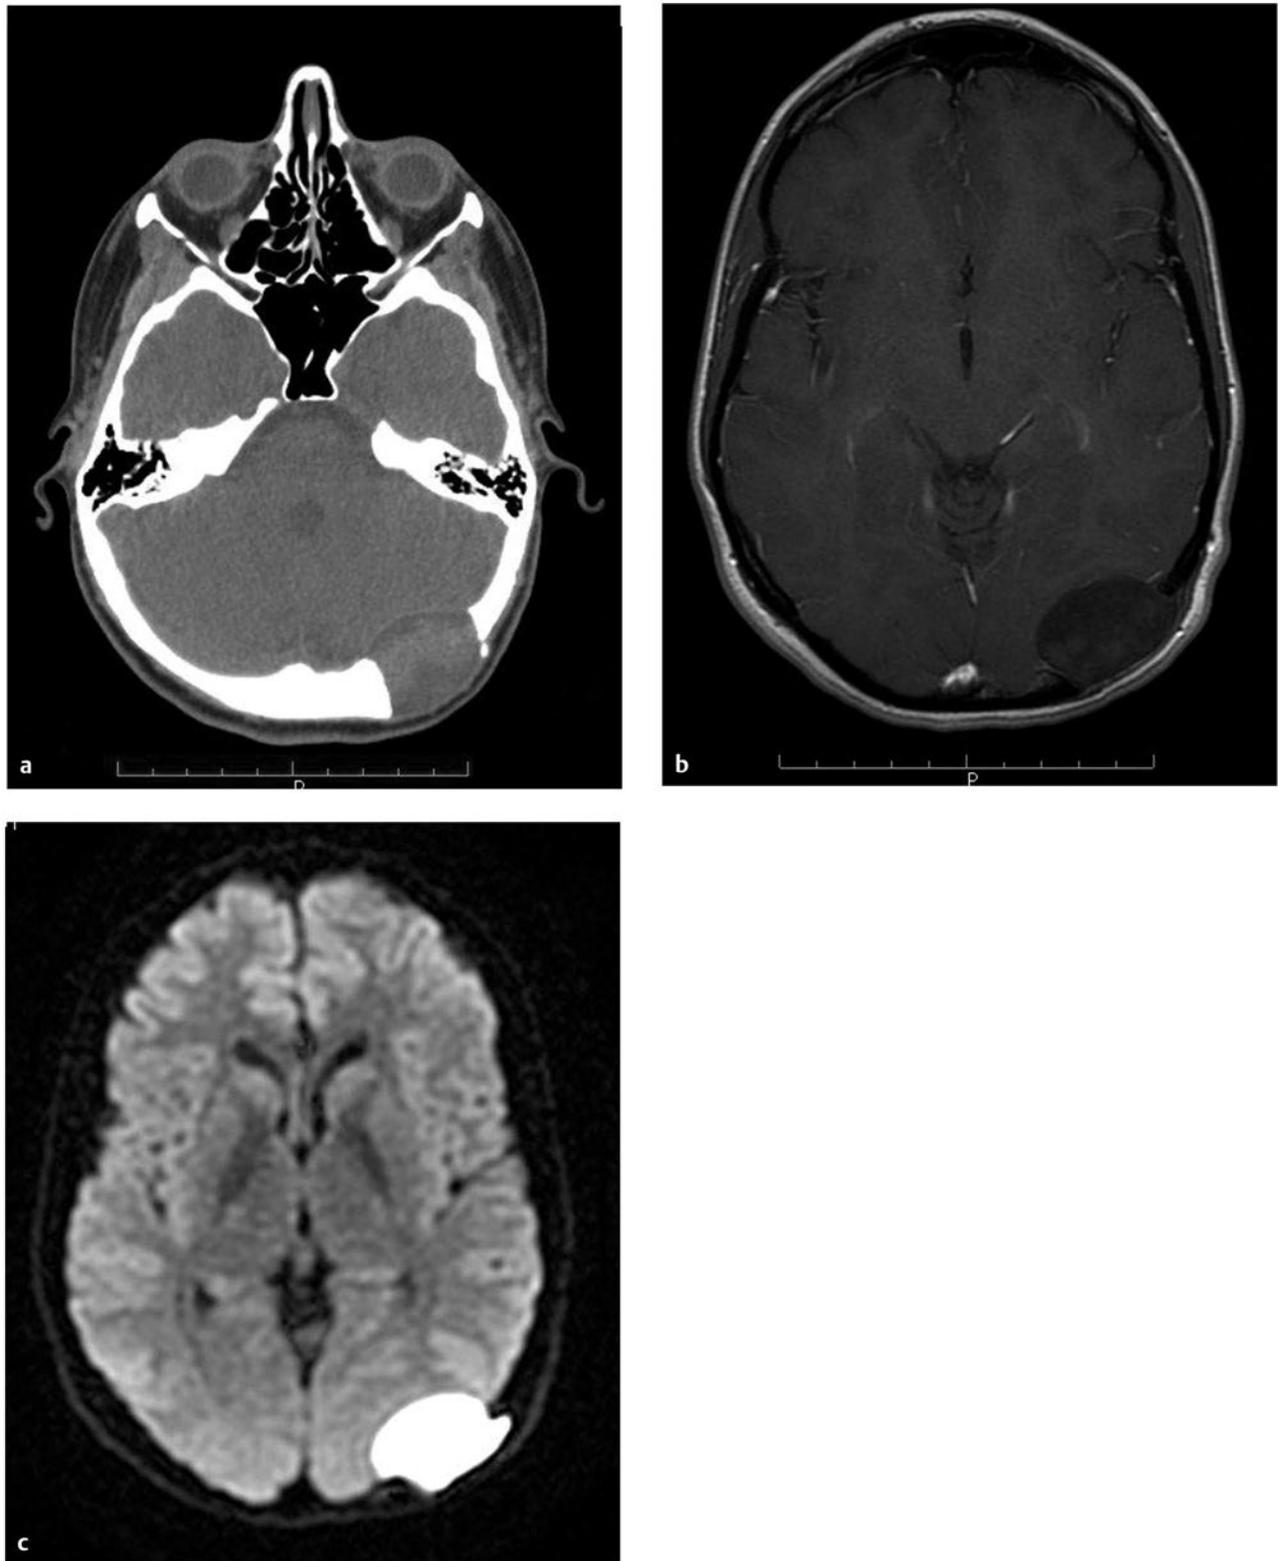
Skull dermoid. This young adult presented with a history of a lump on the back of her head for as long as she could remember. (a) Computed tomography demonstrates a full-thickness skull defect. (b) T1-weighted magnetic resonance (MR) imaging with contrast shows a large nonenhancing occipital mass hypointense to normal brain. (c) Diffusion-weighted MR imaging reveals restricted diffusion, consistent with a dermoid cyst.
